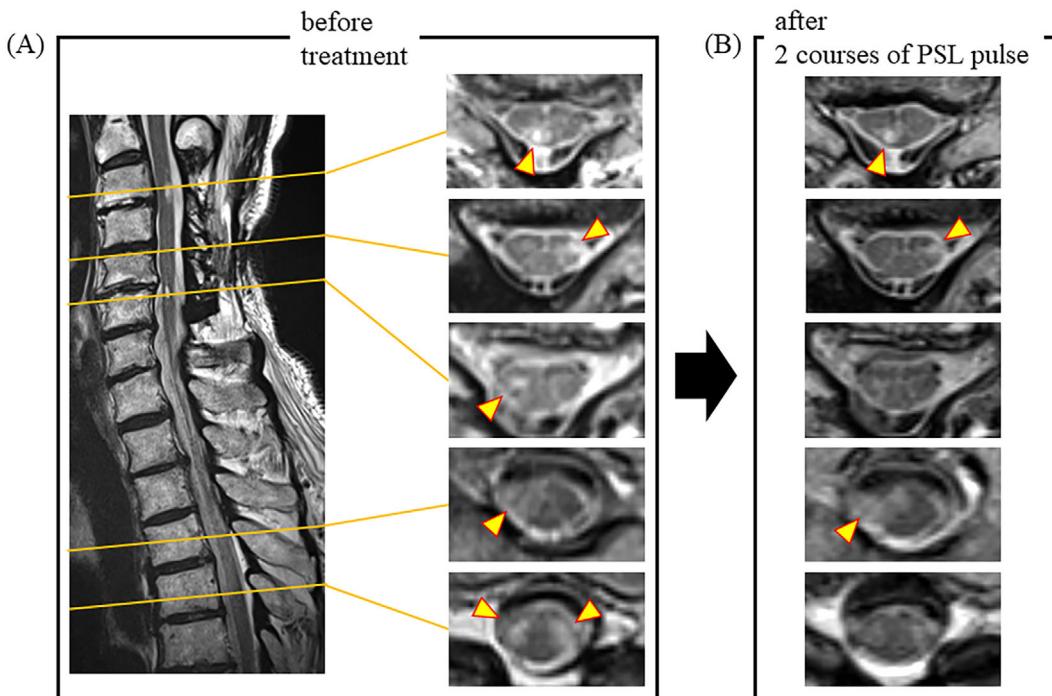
Spinal magnetic resonance imaging findings. (A) Spinal MRI of pretreatment shows abnormal lesions in both the cervical (C3-6) and thoracic (Th4-5) spinal cords (arrowheads). (B) Spinal MRI at posttreatment shows improved abnormal lesions.
